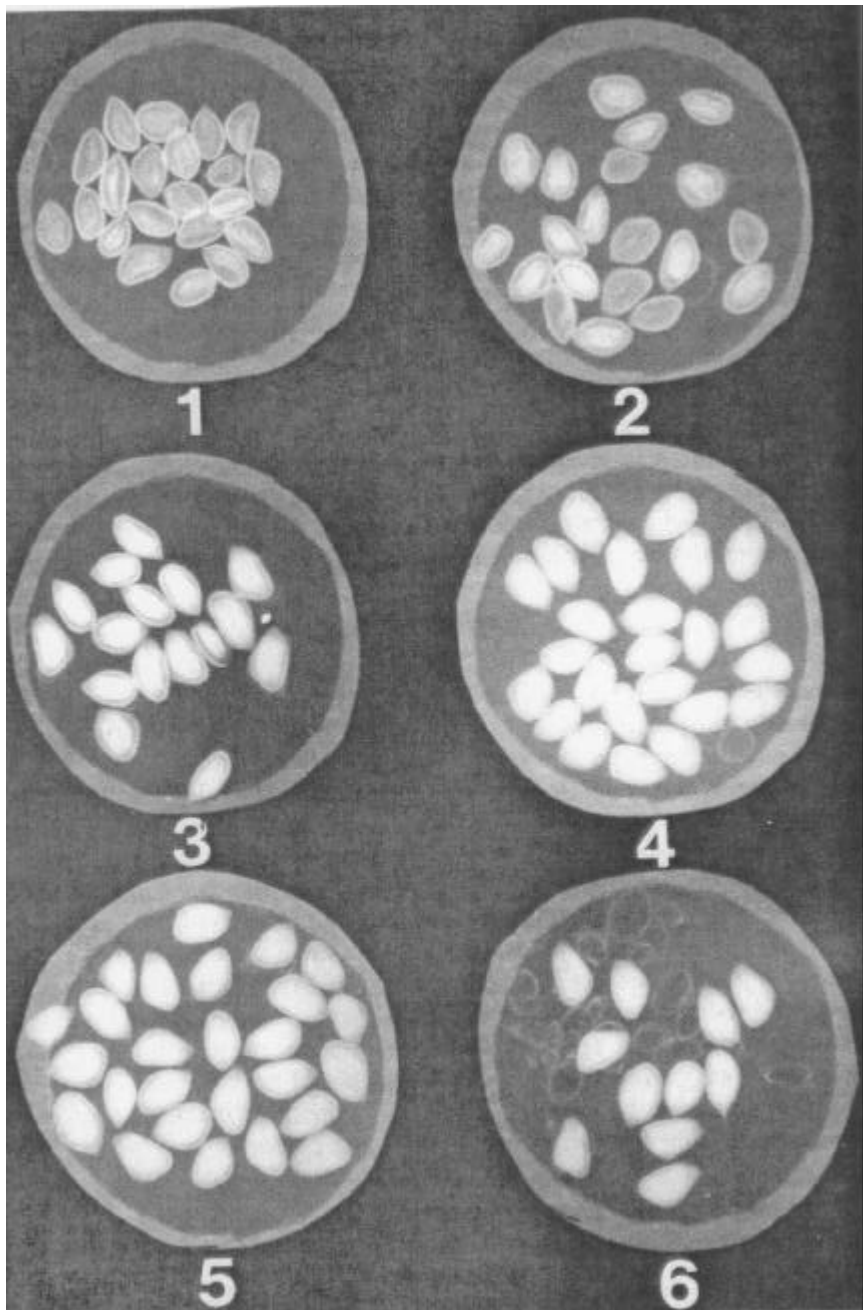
X-rays of slash pine seeds from one tree; cones were collected in 1971 on six dates as follows: (1) July 12, (2) July 26, (3) August 9, (4) August 23, (5) September 7, (6) September 22.
